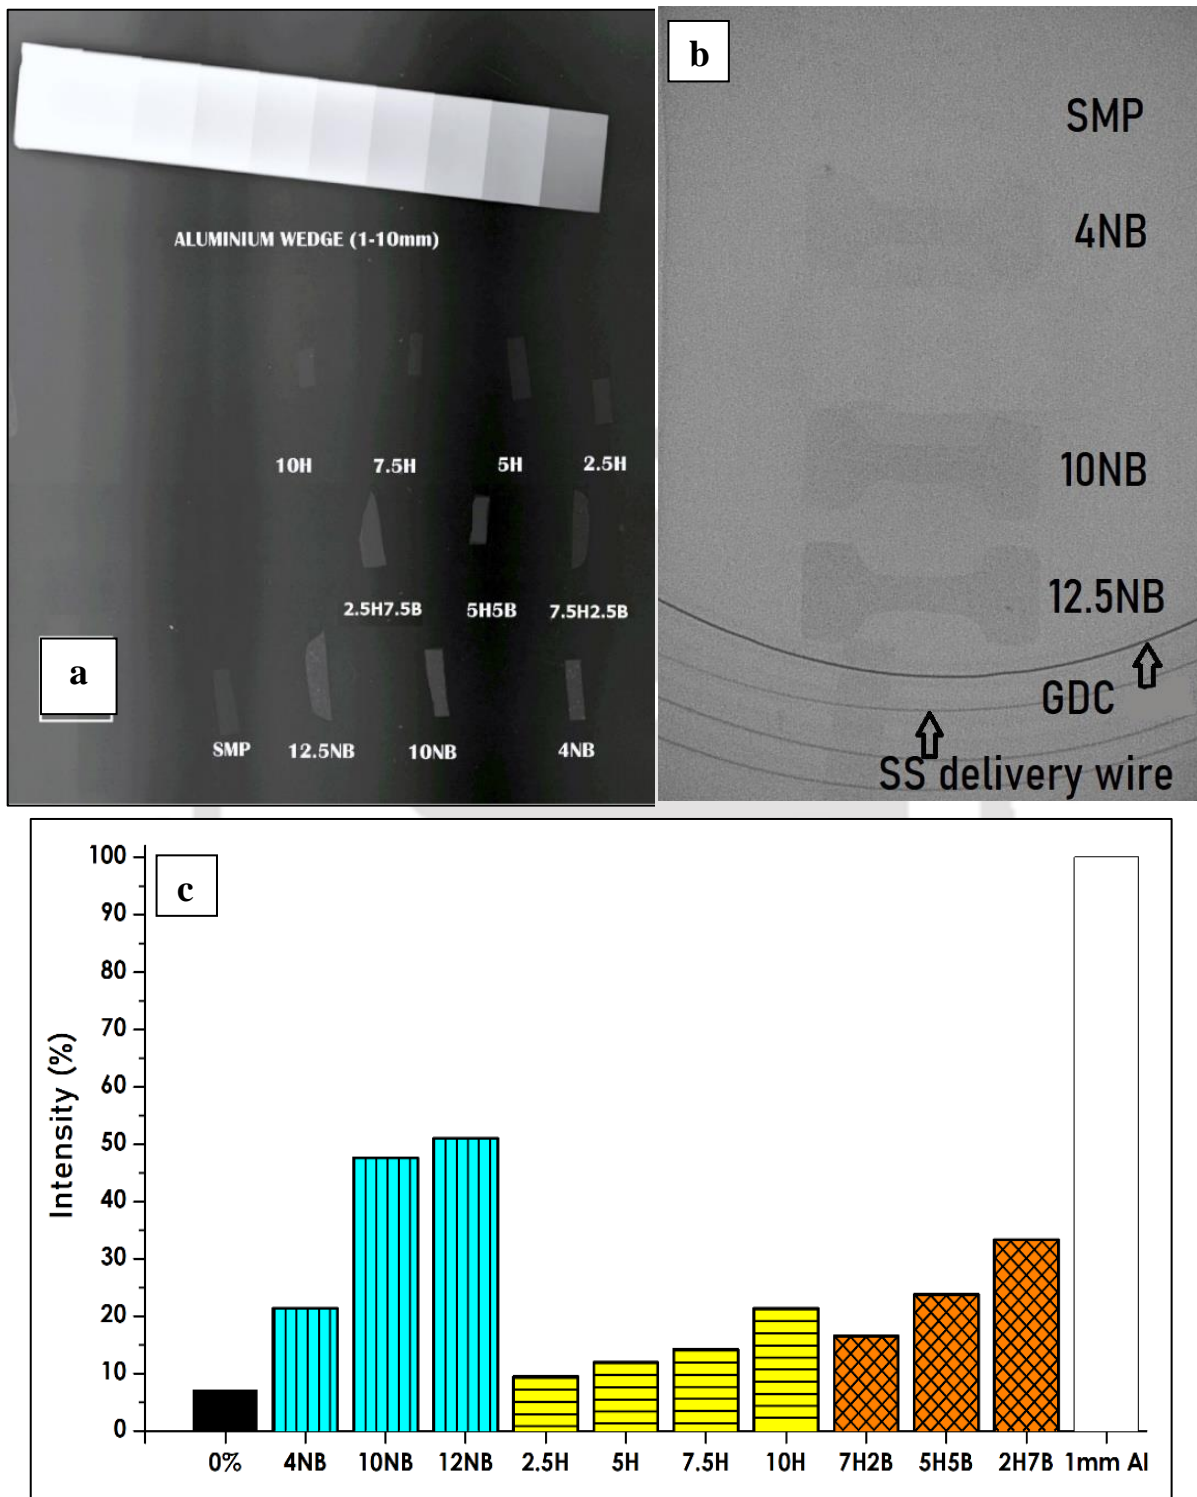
(a) Radiograph of the tested samples with Aluminum wedge; (b) Radiograph of the tested samples with GDC; (c) Intensity of radiopacity of different materials tested in the present study in comparison to 1mm thick Aluminum wedge
